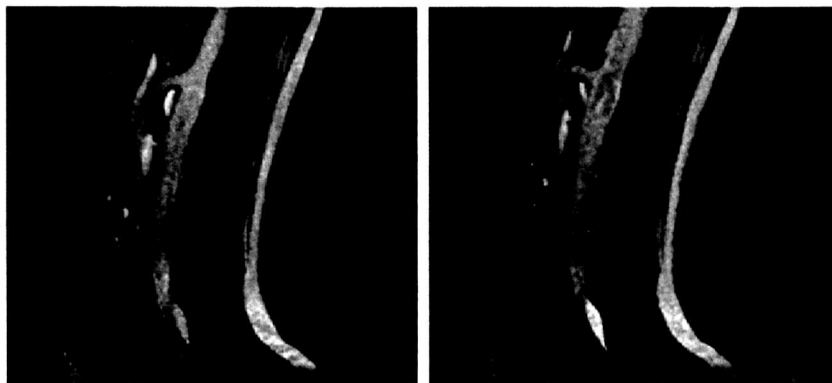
MRI Images showing the SMA whilst breathing in (left) and breathing out (right).
